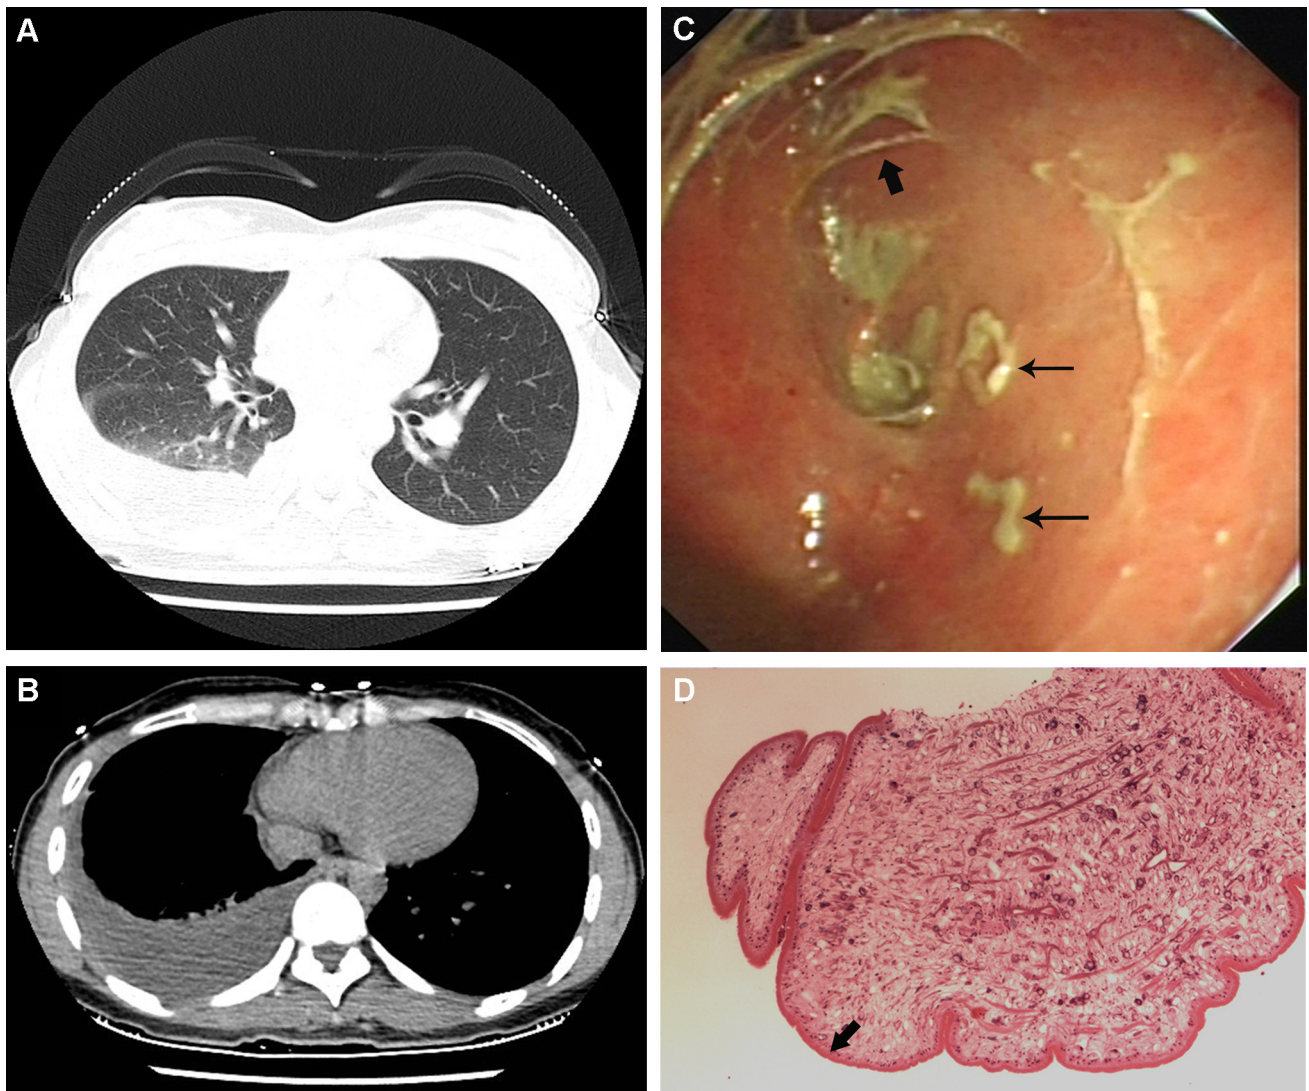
Initial chest CT demonstrated a right pleural effusion (A, B). Semi-rigid thoracoscopy demonstrated two off-white bodies (long arrow), which were detected in the posterior costophrenic angle, and severe inflammation of the right partial pleura and adhering zone of the fiber bundle (short arrow) (C). The sparganum showed a thick eosinophilic uniform tegumental structure (short arrow), and a few calcareous corpuscles and areas of calcification were noted in the body (D).
